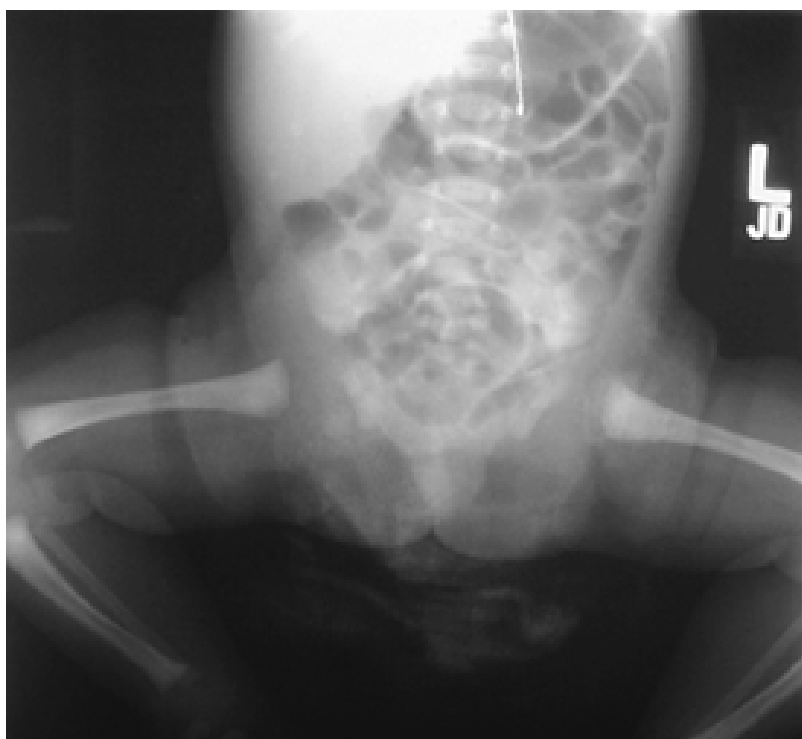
6. The bony pelvis in exstrophy. Note wide pubic diastasis seen on this radiograph
